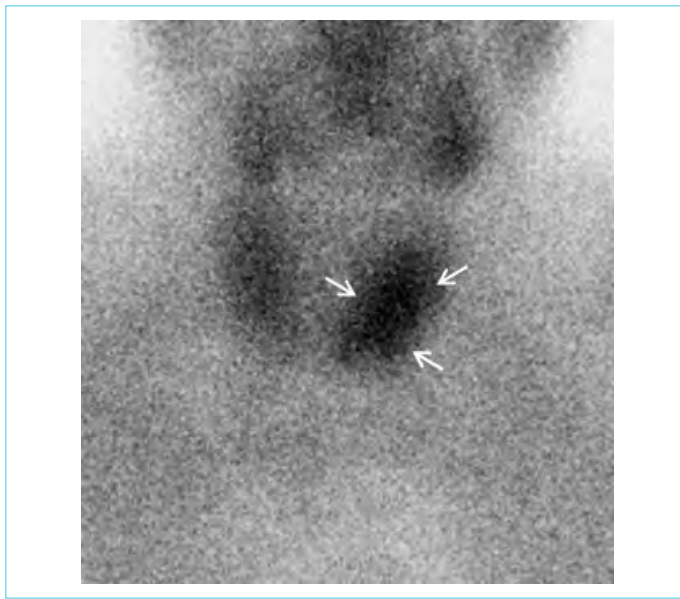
Anterior view of late-phase parathyroid scintigraphy with ^{99m}Tc - sestamibi shows intense activity located on inferior 2/3 of the lobe of the thyroid supporting the diagnosis of parathyroid adenoma (arrows)
